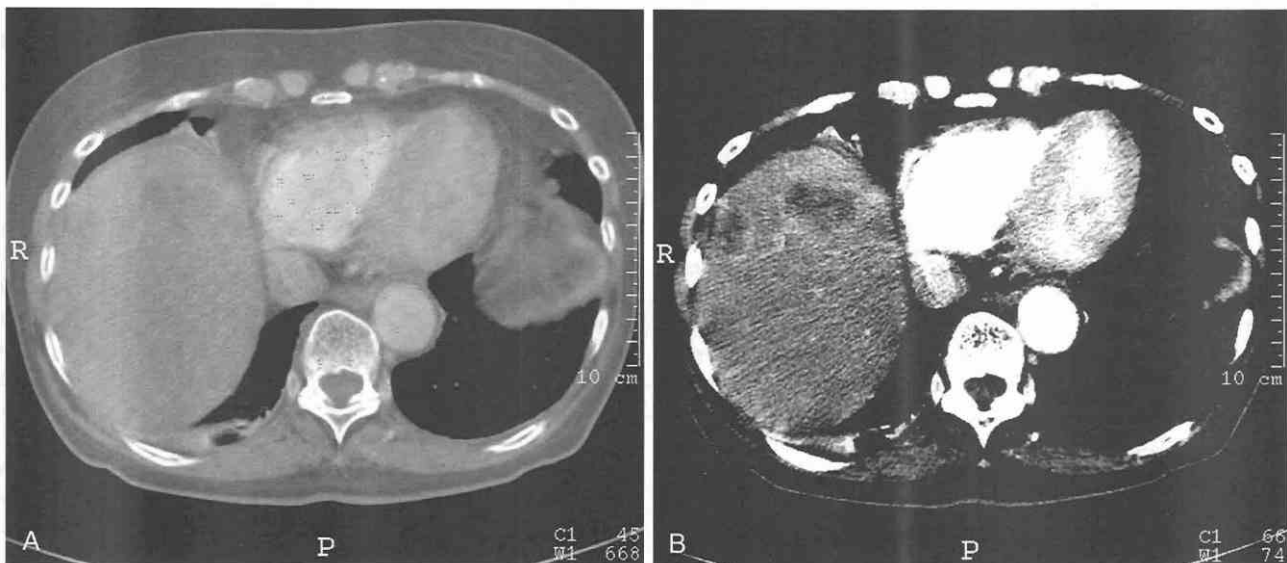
Liver scan. A, Wide window setting; some lesions are blurred and not visible. B, A more appropriate window setting enhances the presence of lesions. (MX8000 multislice CT images courtesy of Dr. John Haaga.)
